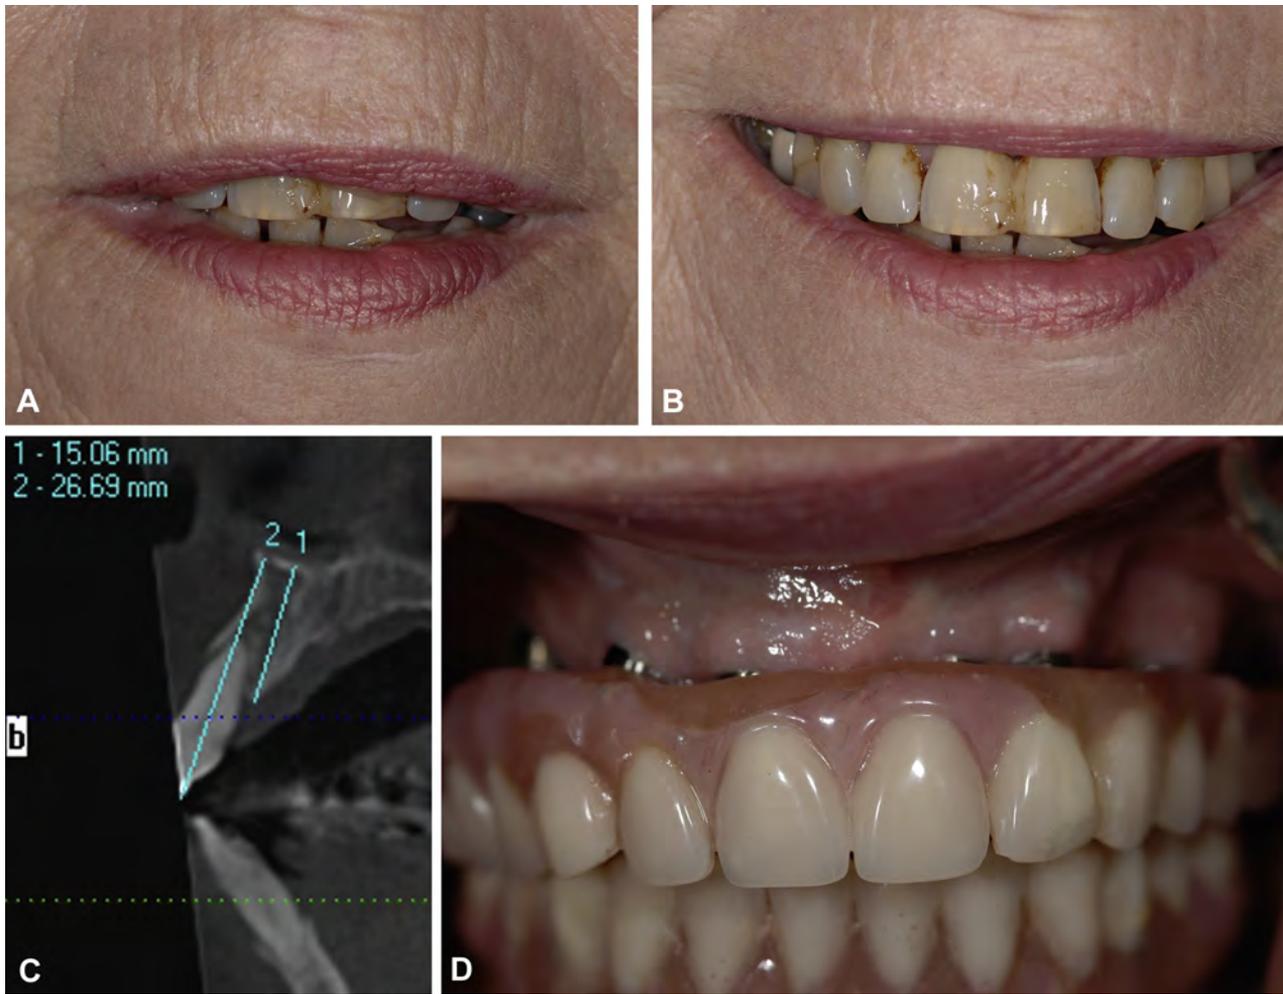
A, Appearance of patient with lips slightly apart and relaxed, with an incisor show of 3 mm. B, Smile line of patient at the level of the gingival margin of a 10.5-mm-long central incisor. C, Cone-beam computed tomographic section showing the 15-mm-long implant site with 11 mm of space between the crest and the incisor edge. D, Provisional hybrid prosthesis with the teeth positioned anterior to the ridge to match the patient's preoperative appearance. Notice there is space available for hygiene. (Fig 1 continued on next page.)
